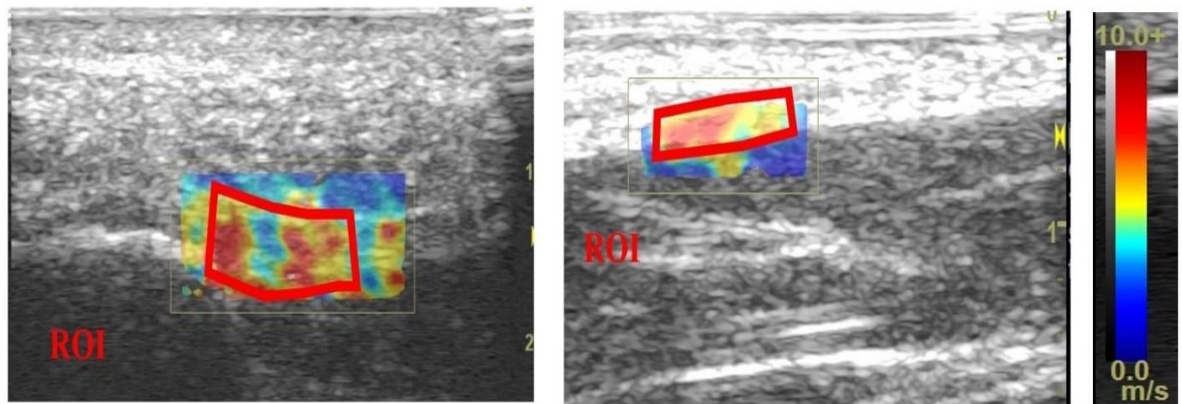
ROI; Region of Interest. Representation of shear wave elastography ultrasound images to measure PF stiffness at the proximal (left) and distal (right) sites. The color legend on the right represents the shear wave velocity in meters per second. Greatest velocity (stiffer tissue) is shown in red, lowest velocity (less stiff tissue) is shown in blue.
